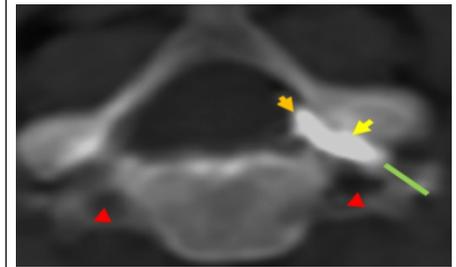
In an interscalene block the needle was placed at the level of C6 and deltoid – biceps contractions were evoked at 0.4Ma. CT contrast delineated the cervical nerve root and the lateral cervical epidural space in the axial section
